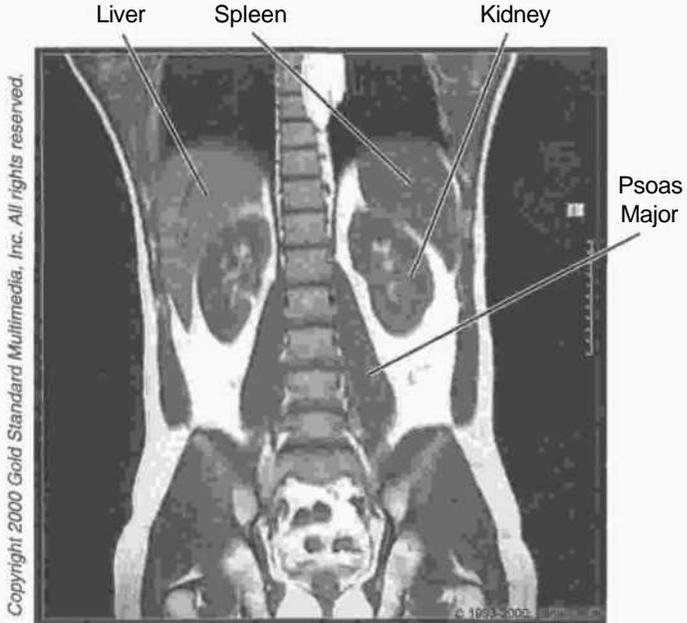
Abdomen: MRI, Coronal
